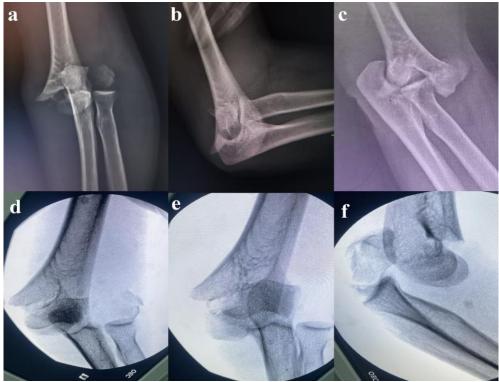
(a, b) Initial elbow radiographs obtained at the emergency room, poor quality images but the only available preproduction images. (c-f) Post elbow trial of reduction radiographs in different views demonstrated non-reduced elbow
